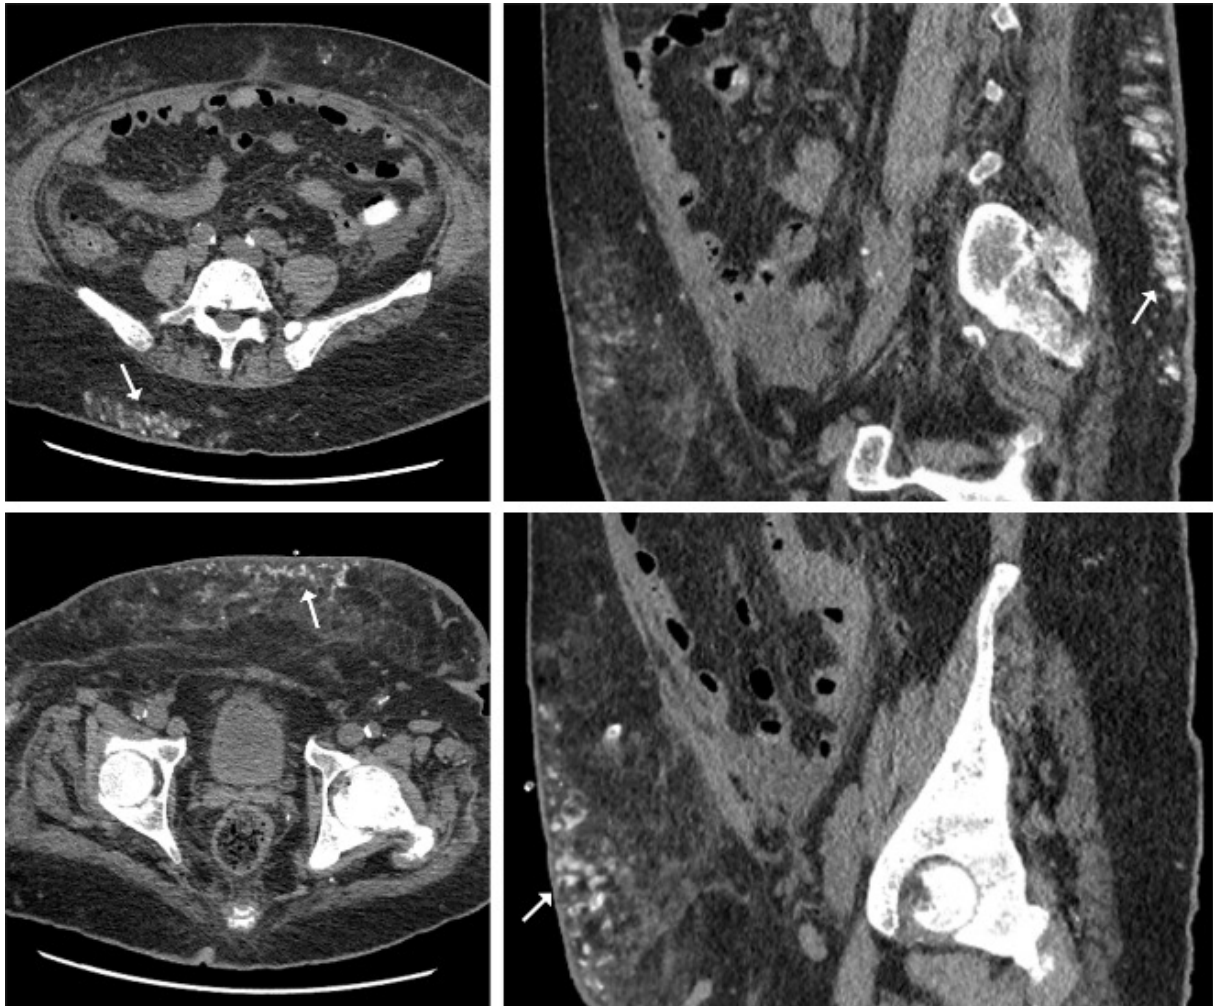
Non-contrast computed tomography of the patient's abdomen and pelvis shows subcutaneous small arteriole calcifications of the lower abdomen (white arrows), suggestive of calcific uraemic arteriopathy.*
